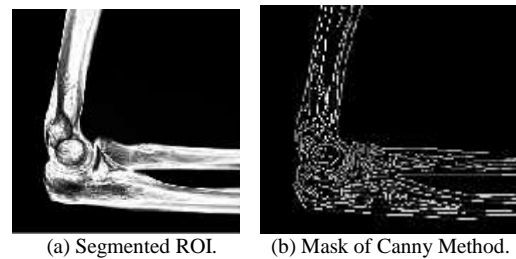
Edge Perceived Bone. (a) Indicates the Segmented Bone from Actual X-ray Image. (b) Shows the Edge Detected Image through Canny Method.
